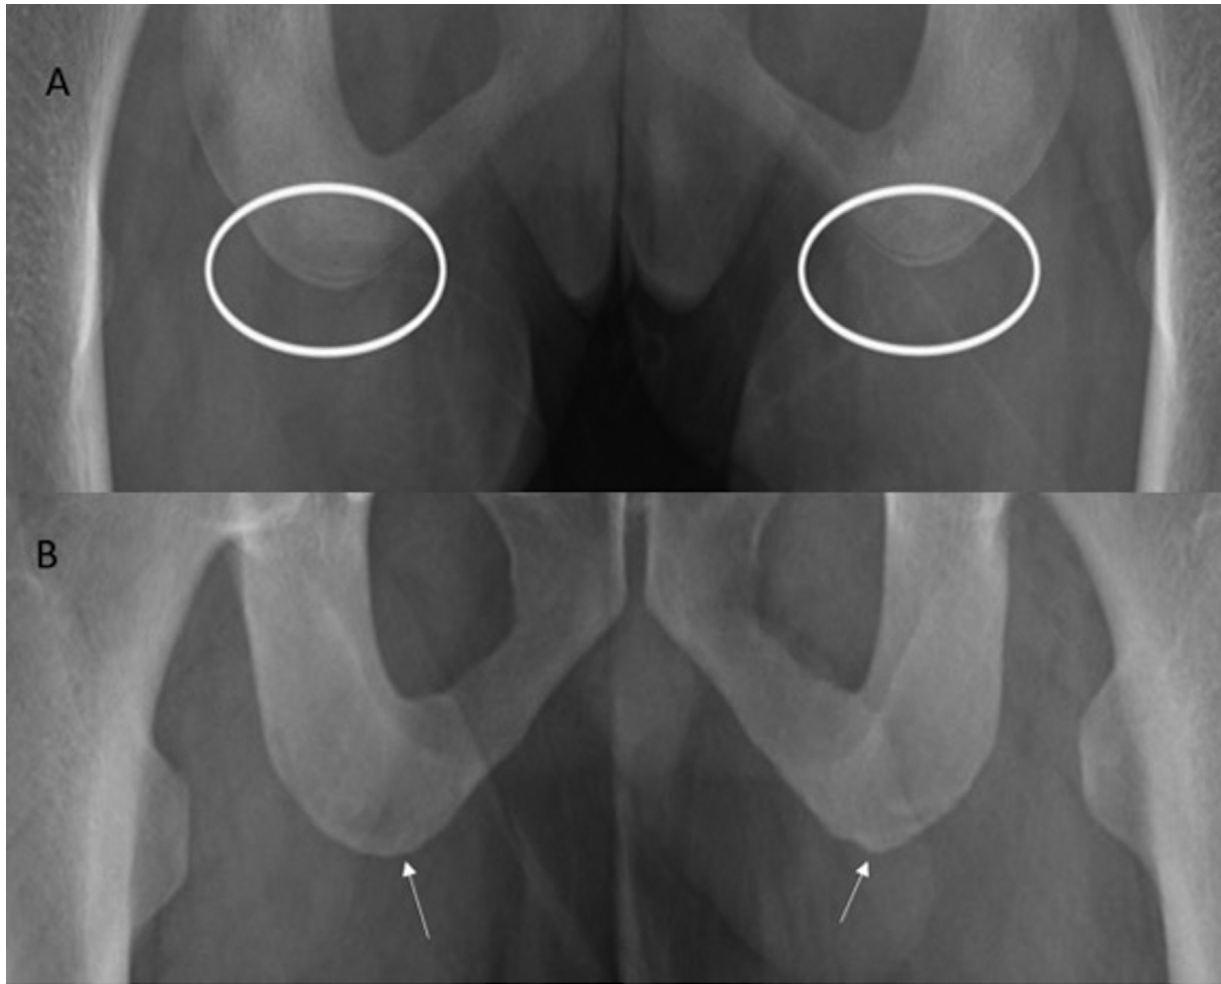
Anteroposterior view of pelvic radiographs of 16-year-old male showing (A) unfused bilateral ischial tuberosities (white circles). (B) Completely fused bilateral ischial tuberosities (white arrows) in an 18-year-old boy.
